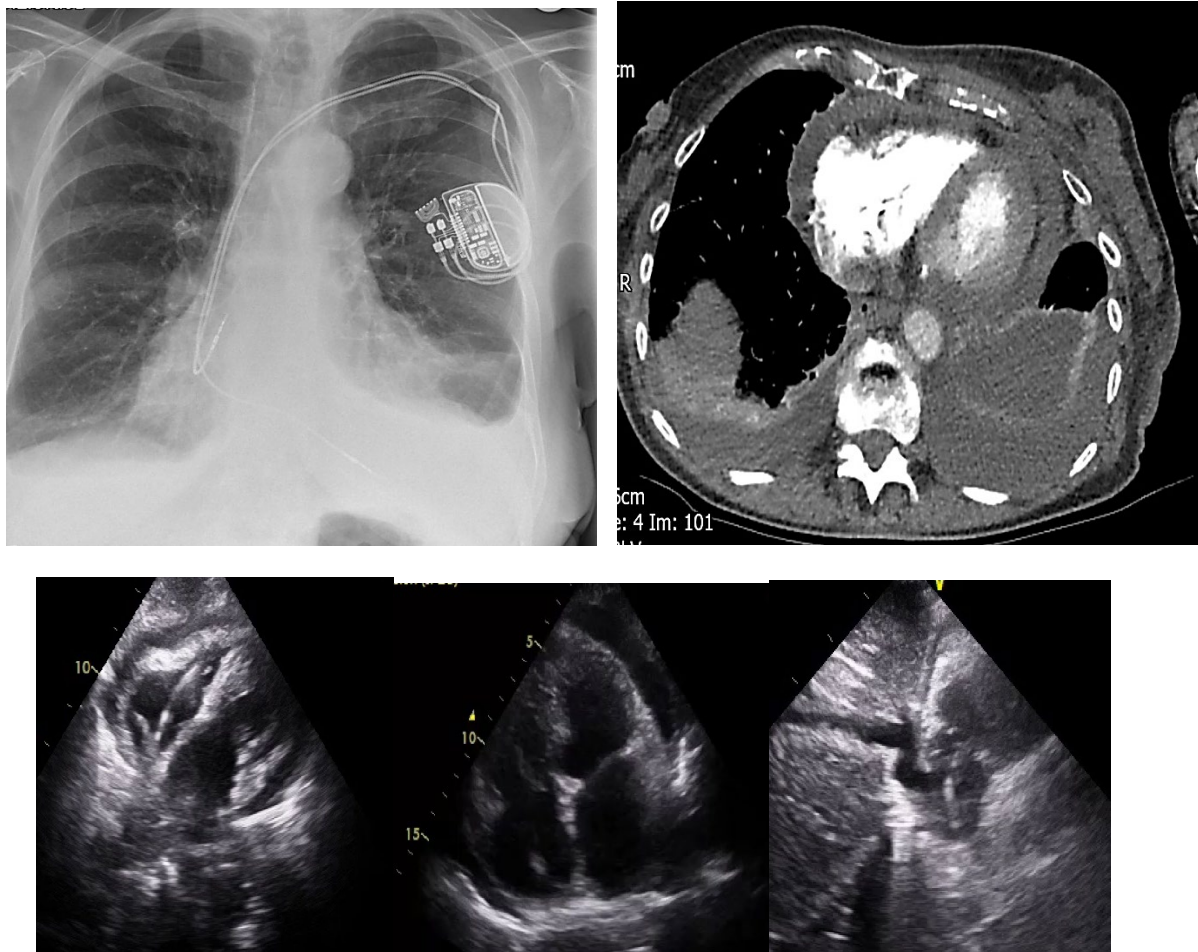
(A) CXR demonstrates haemo-pneumothorax with dual chamber pacemaker leads in position. (B) CT showing bilateral pleural effusion and pericardial effusion. (C) Echocardiography from subcoastal and apical windows showing moderate pericardial effusion, with inferior vena cava (IVC) collapse more than 50%.
